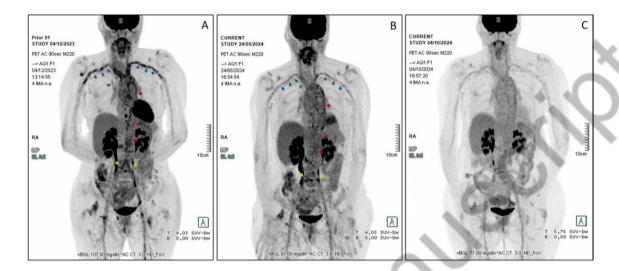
<sup>18</sup>FDG-PET in the coronal view at different time points. (1A) At initial presentation: maximum standardized uptake value (SUVmax) of 4.8 in the aortic arch and descending aorta (red arrows), 5.4 in the brachiocephalic trunk (green arrow), 4.7 in the left subclavian artery (blue arrows), 4.3 in the right subclavian artery (blue arrows), and 2.8 bilaterally in the internal mammary arteries (purple arrow). (1B) Before antibiotic treatment: SUVmax of 4.6 in the aortic arch and descending aorta. (1C) Two months after antibiotic treatment: SUVmax of 4.1 in the aortic arch and descending aorta.
